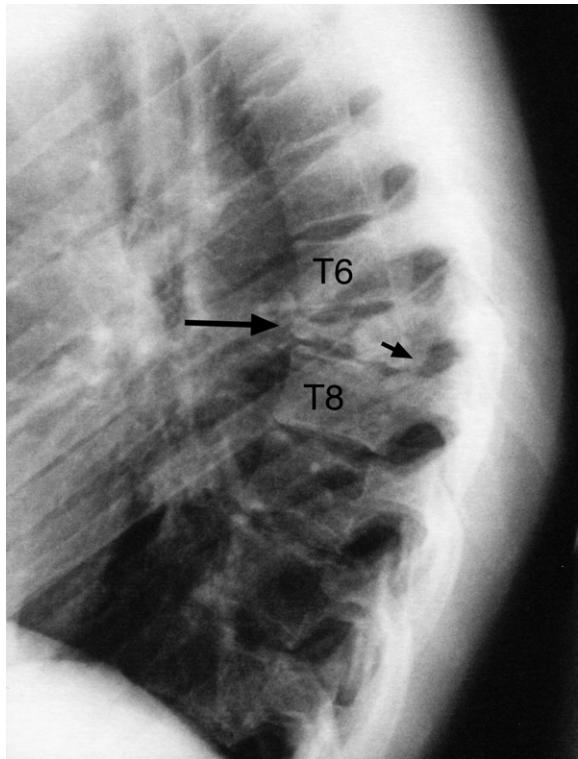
Thoracic spine lateral plain X-ray image. Note the grossly compressed T7 vertebral body that appears wedge shaped causing a kyphosis at this level. Also, there is an opacity in the T7-T8 intervertebral foramen (black arrow) suggesting that there may be a burst fracture with retropulsion of bone into the spinal canal. There also appears to be a fracture of the superior endplate of the T8 vertebra.
